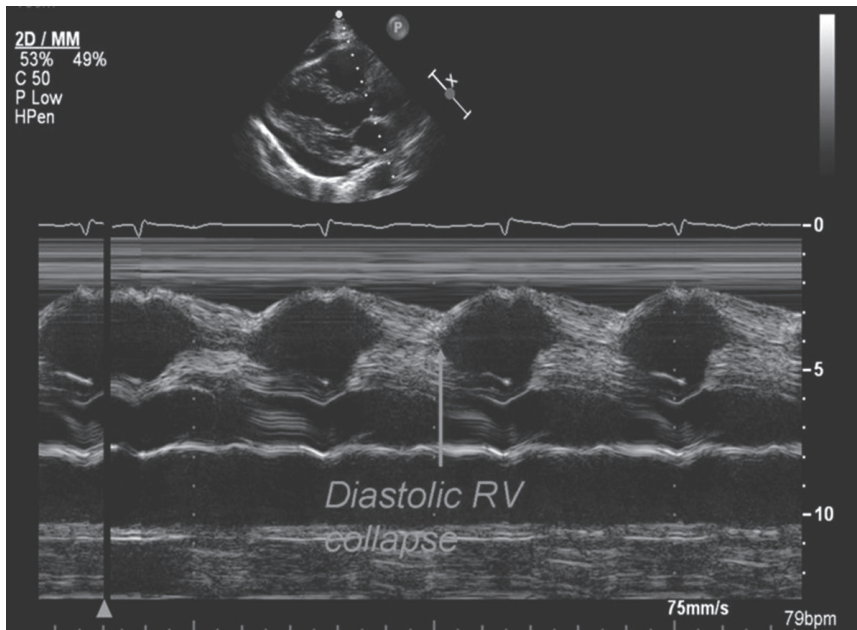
Echocardiogram showing right ventricular diastolic collapse in cardiac tamponade
